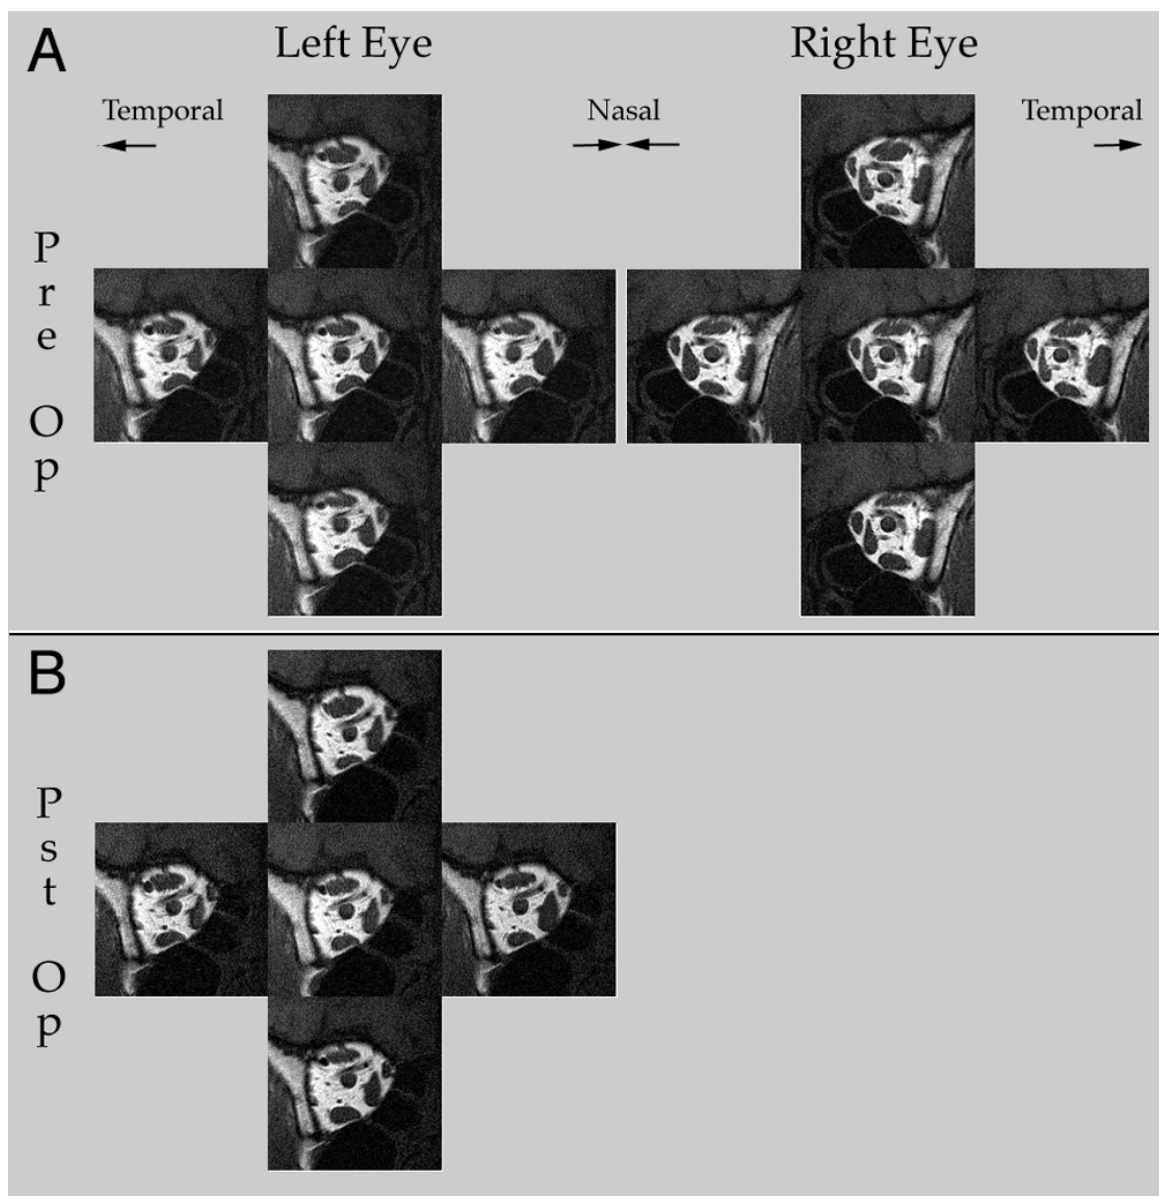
Patient TS, fixing along the orbital axis, and up, down, temporal, and nasal over about a 15° horizontal and vertical range. Each panel is an MRI scan plane, perpendicular to the orbital axis and 15 mm posterior to the globe-optic nerve junction. A: Even over this modest range of gaze, in the normal right eye, each muscle can be seen to contract (thicken) in its field of action. In particular, the right LR approximately doubles its cross-section during abduction, and the right SO approximately doubles its cross-section during depression. In contrast, the left LR and left SO show no contractility. Measurement shows that left MR contractility is also sub-normal. Comparing cross-sections in the two eyes, shows that the left LR is severely , and the LSO moderately atrophic. B: Following augmented vertical rectus transposition, little is changed in these posterior slices, although we note that the LSO has regained some contractility during the 6 weeks between scans.
